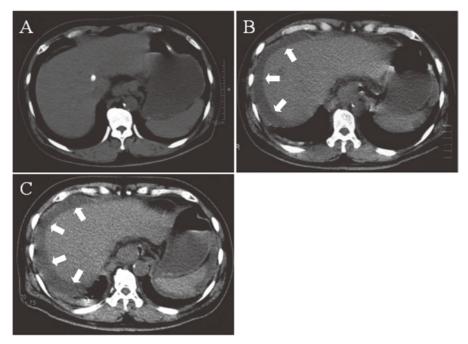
Computed tomography of the abdomen (A: on admission, B: 11 h later, C: 21 h later)
